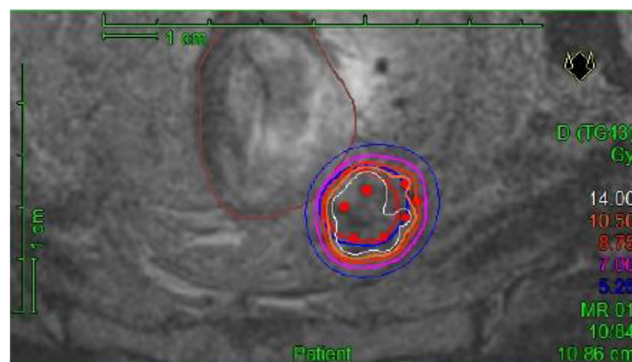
Pelvic magnetic resonance imaging (MRI) scan with catheters in situ showing the dose distribution around the mesorectal nodule abutting the rectum (case 6).
